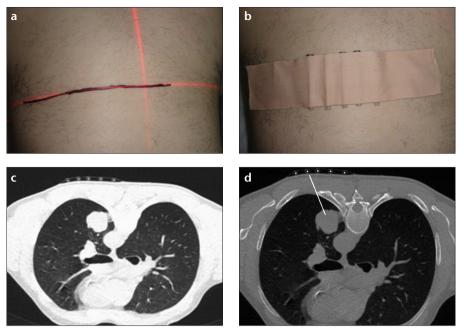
a-d. Marking of the biopsy entry site on skin and CT images.
